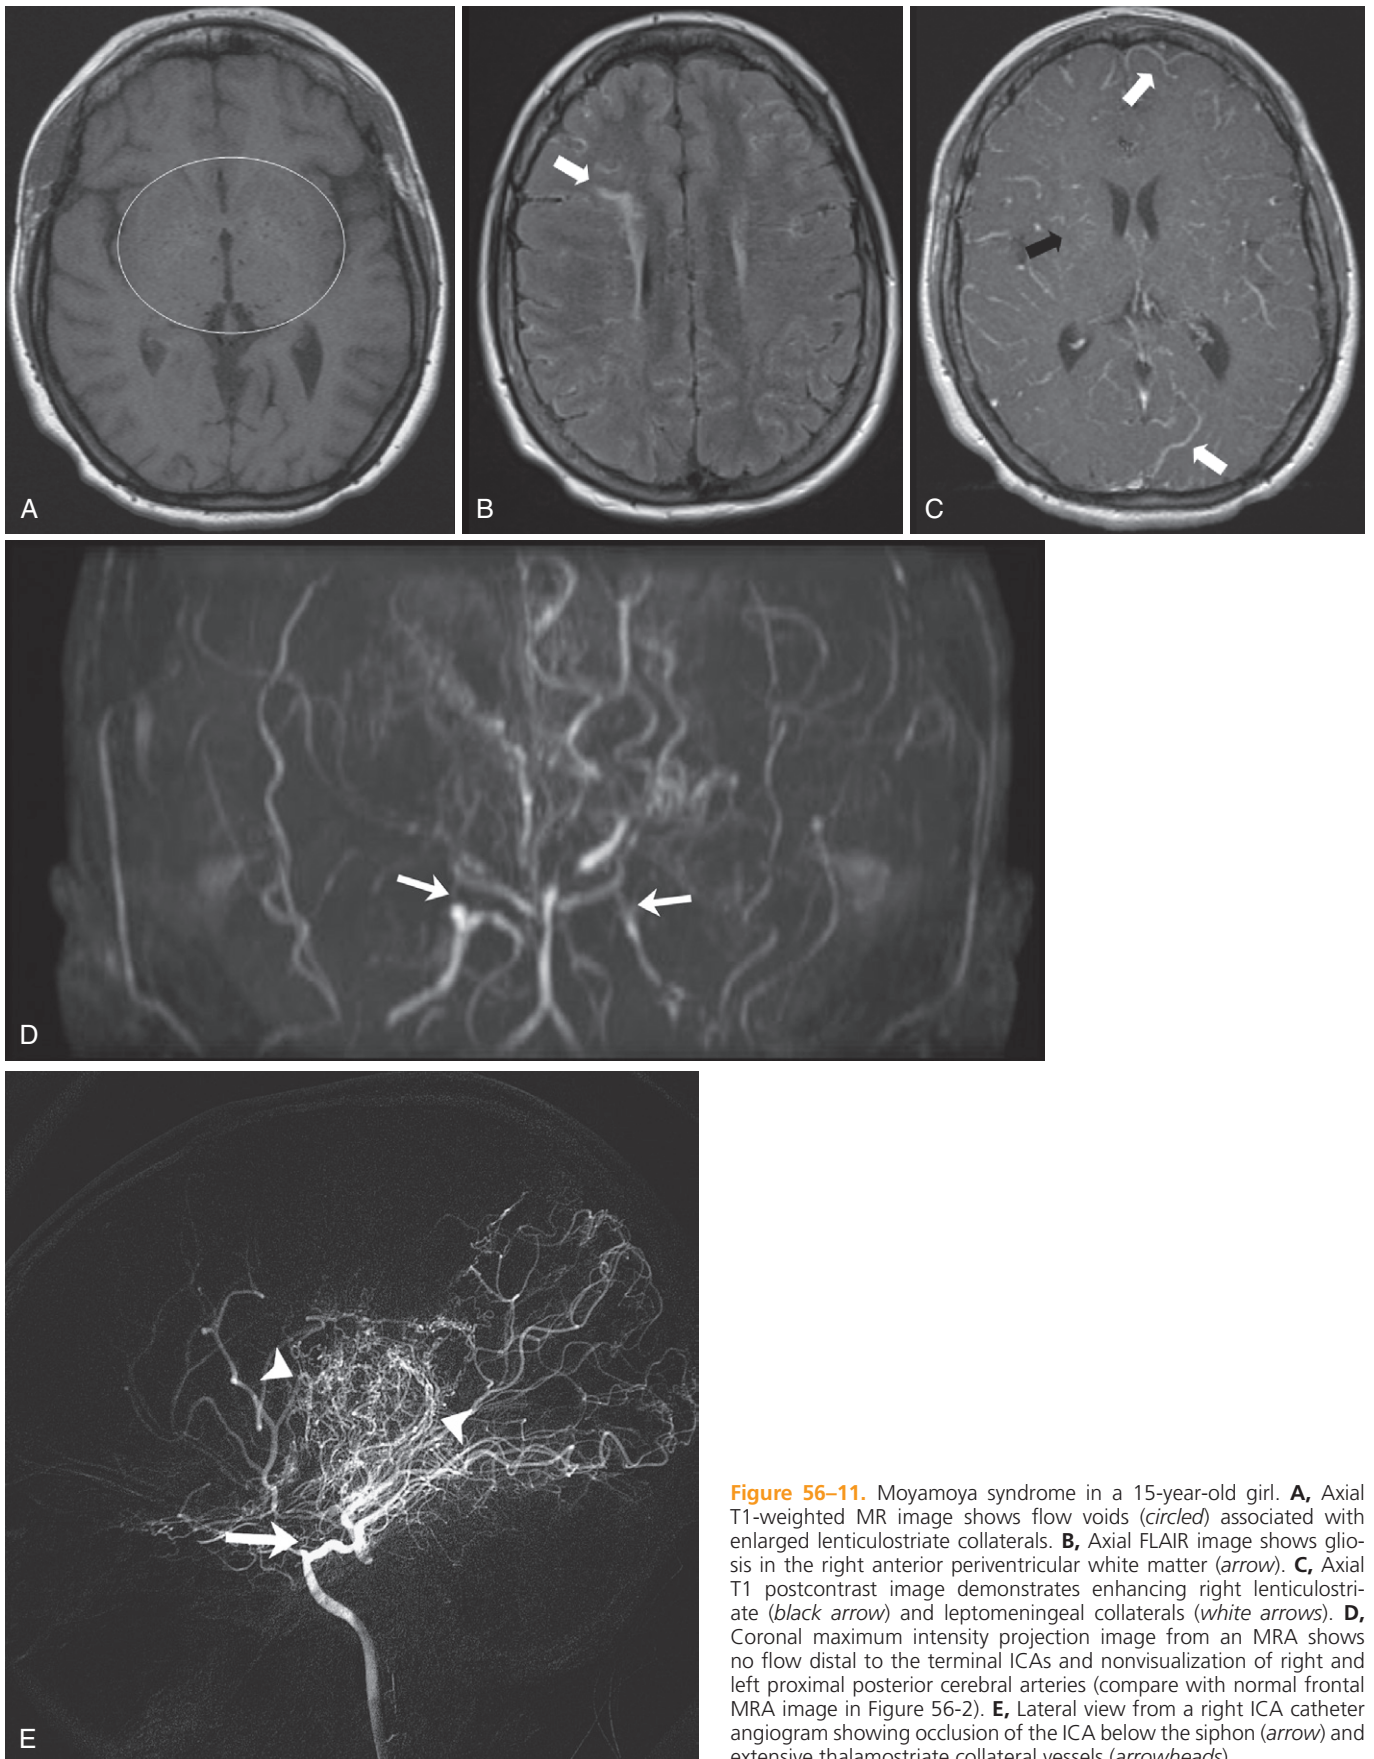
Moyamoya syndrome in a 15-year-old girl. A, Axial T1-weighted MR image shows flow voids (circled) associated with enlarged lenticulostriate collaterals. B, Axial FLAIR image shows gliosis in the right anterior periventricular white matter (arrow). C, Axial T1 postcontrast image demonstrates enhancing right lenticulostriate (black arrow) and leptomeningeal collaterals (white arrows). D, Coronal maximum intensity projection image from an MRA shows no flow distal to the terminal ICAs and nonvisualization of right and left proximal posterior cerebral arteries (compare with normal frontal MRA image in Figure 56-2). E, Lateral view from a right ICA catheter angiogram showing occlusion of the ICA below the siphon (arrow) and extensive thalamostriate collateral vessels (arrowheads).
